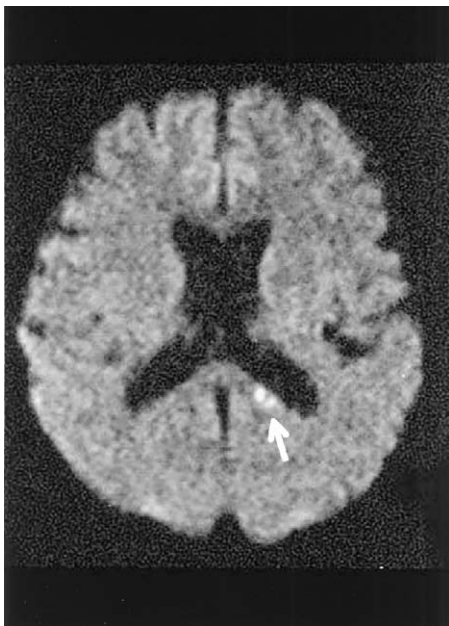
An axial DWI shows a hyperintense lesion in the left splenium of the corpus callosum (arrow).
